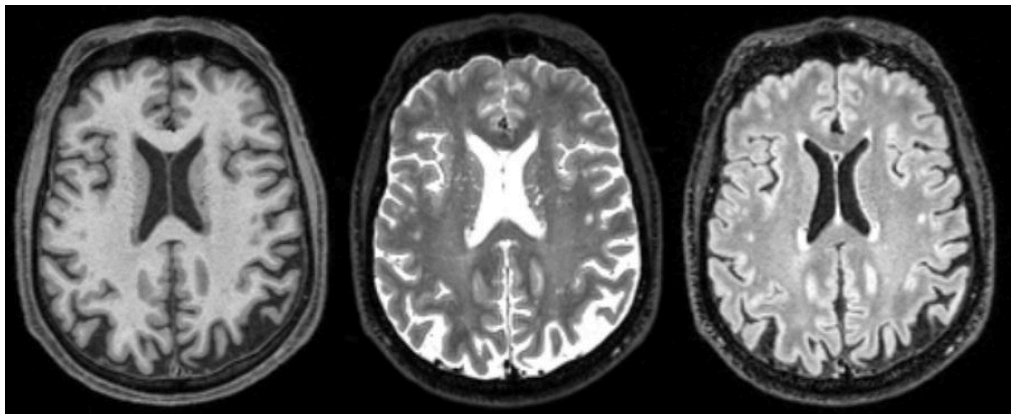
(Left) T1-weighted, (Middle) T2-weighted and (Right) FLAIR MRI brain
